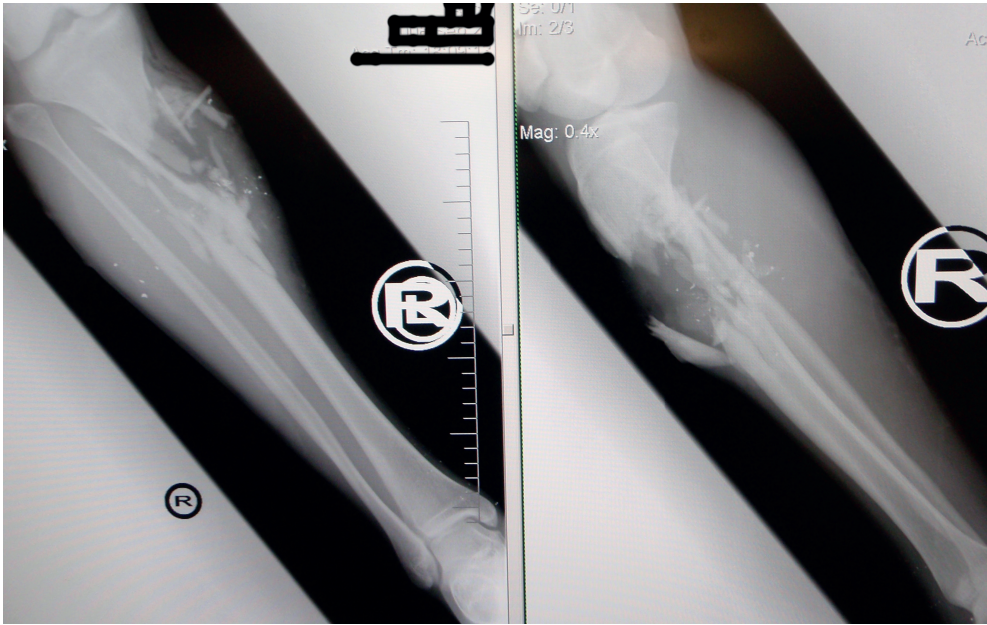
X-ray of proximal compound tibial fracture
